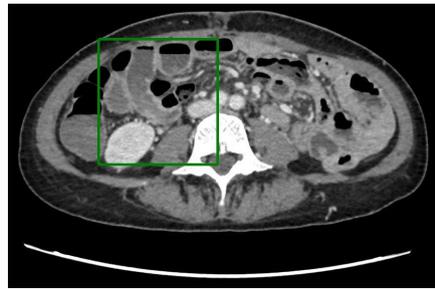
Angio-CT revealing the mid-ileal blushing.
